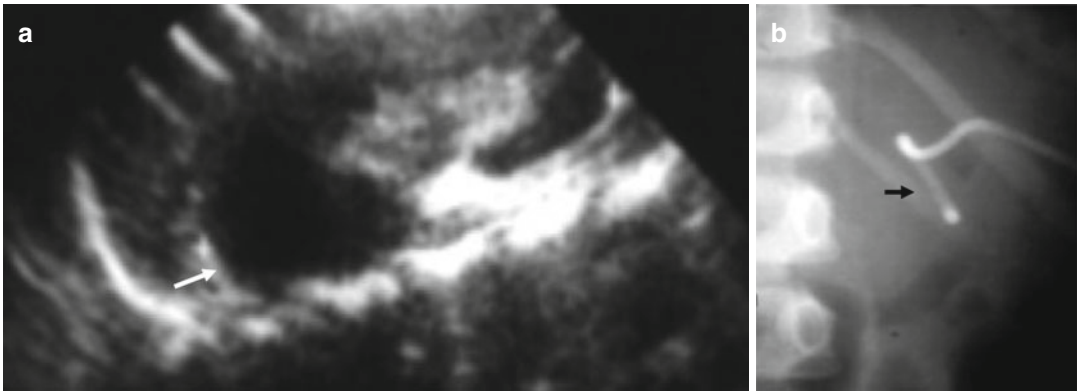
(a, b) US (a) shows a renal abscess (*white arrow*) of the upper pole requiring drainage. An abdominal plain film (b) is required to check for drainage positioning (*black arrow*)
